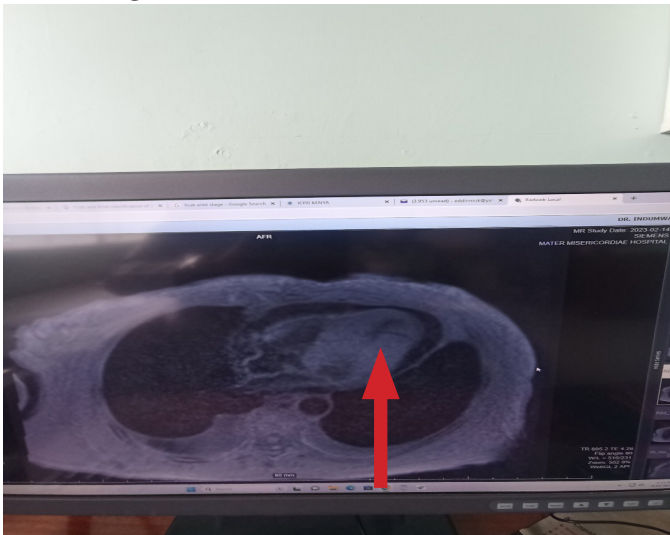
MRI T1 weighted –showing wall thickening
